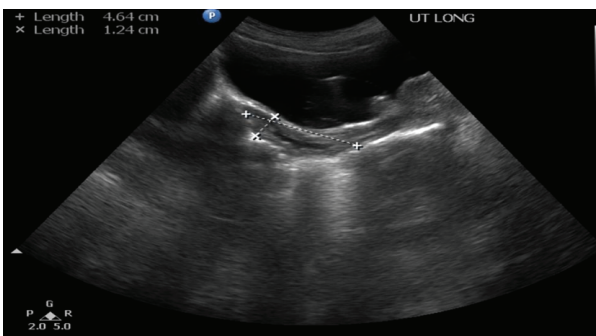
Pelvic ultrasound imaging: Normal size and shape of uterus with pressure effect from highly calcified mass at the level of vagina of unknown origin
